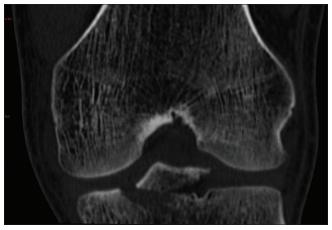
Computed tomography scan of knee joint showing displaced tibial eminence fracture
